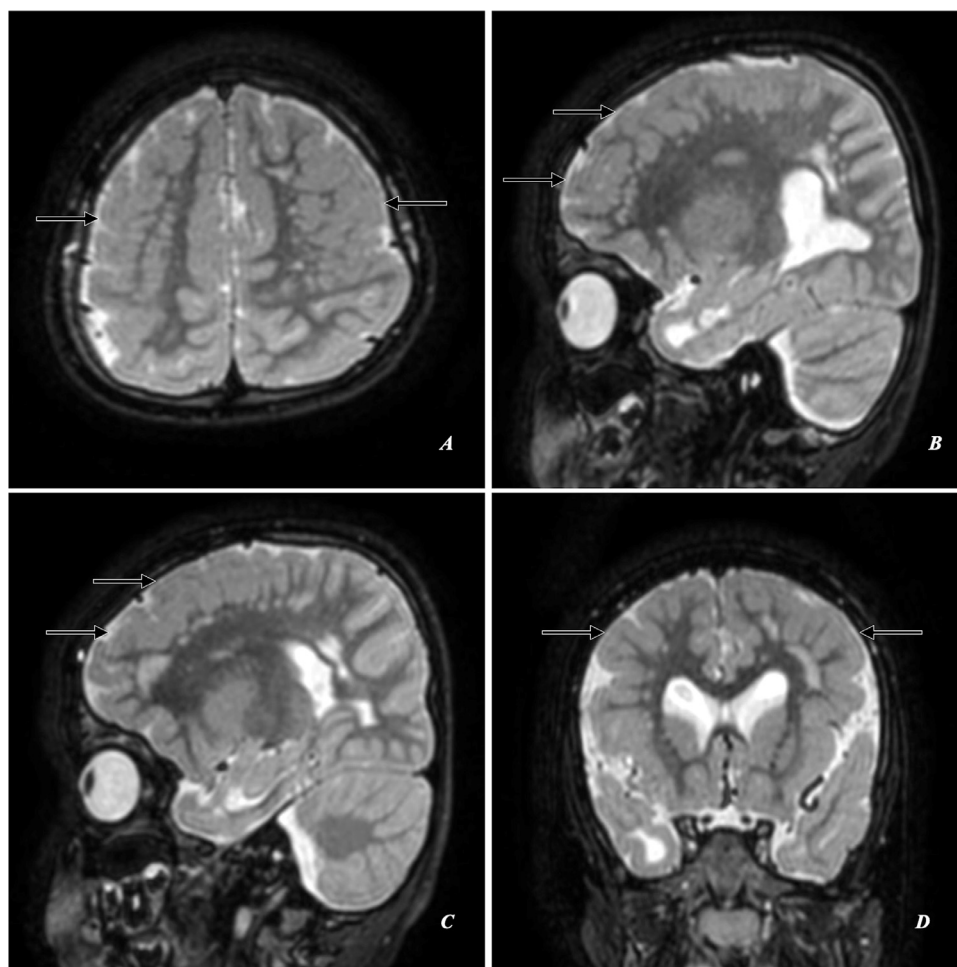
(A-D): A 6-year-old female was referred to a neurology clinic due to severe developmental delays, hypotonia, and recurrent intractable seizures. Magnetic resonance imaging (MRI) of the brain: T2-weighted (T2W) shows thick cortices in the bilateral high frontoparietal lobes (predominantly in bilateral high frontal lobes) with micro-lobulated or multi-nodular gyri/surface of the “Pebble/Cobblestone complex” with sparse cortical sulci (arrows).
